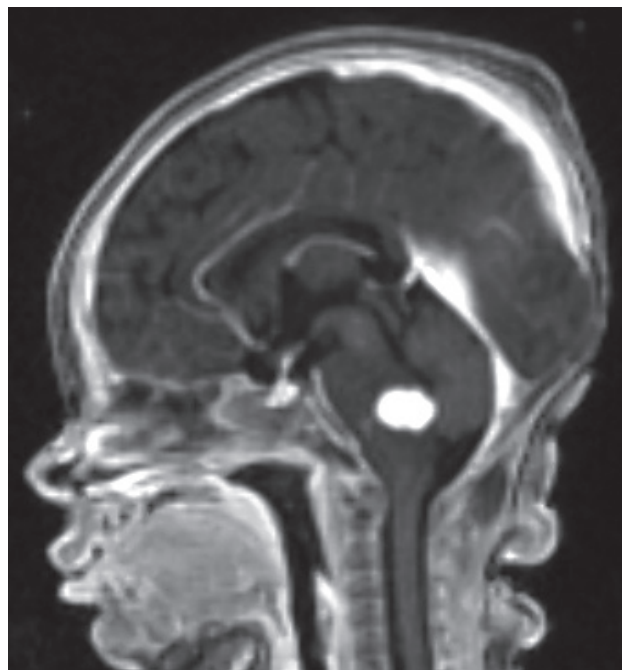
Brain MRI showing a highly vascularised brain stem tumour (white spot) first suspected for glioma.
